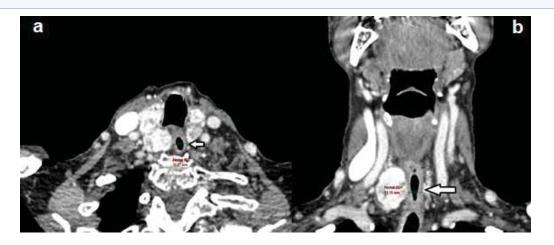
Contrast-enhanced neck CT, axial (a) and coronal (b), showing (arrow) normal esophageal diameter after RAI (minimum diameter estimated at 11.3 mm).
